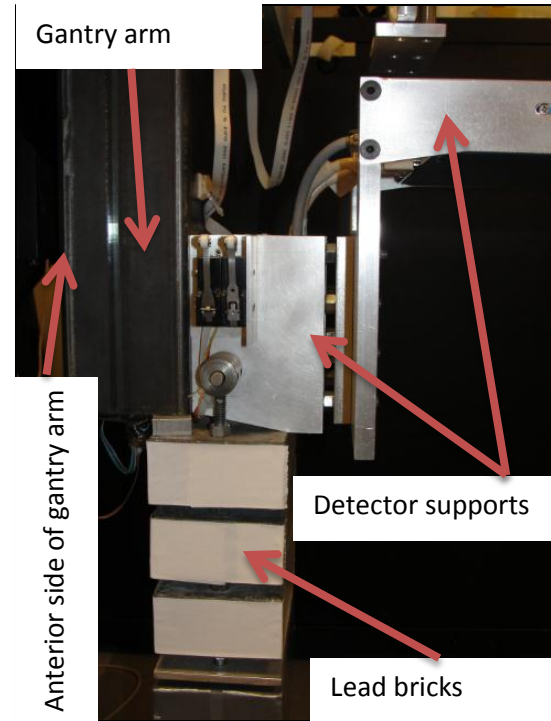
Photograph of X-ray detector housing
